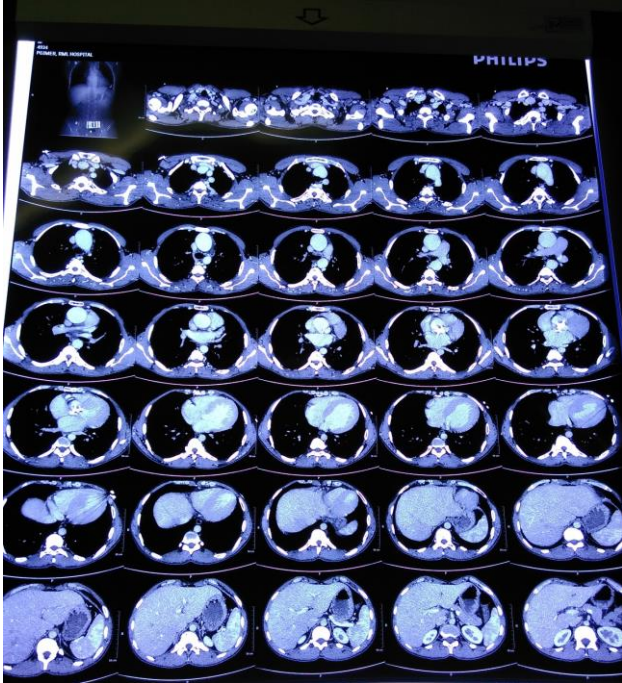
CT chest and aortography showing Coarctation of aorta.
